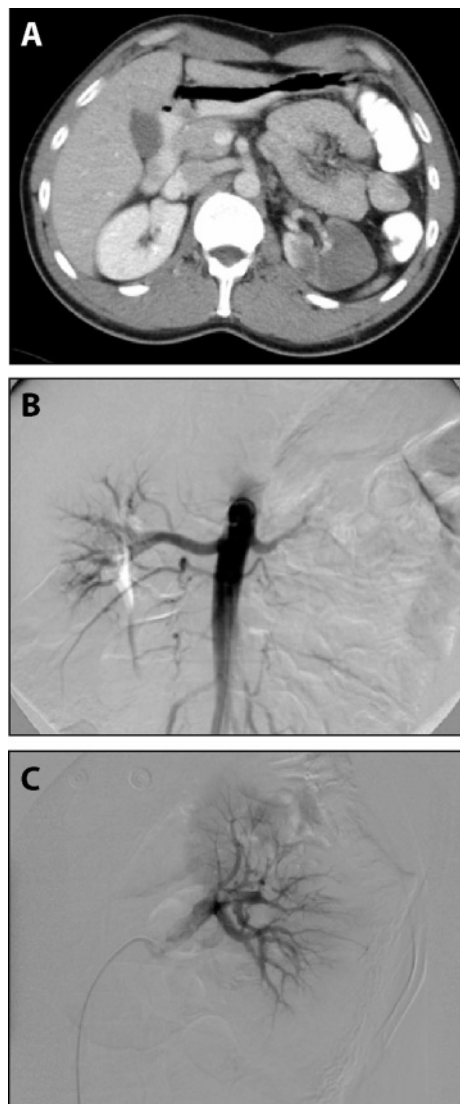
(A) Contrast-enhanced abdominal CT during the late venous phase showing a perfusion deficit of the middle and lower pole of the left kidney. (B) Digital subtraction angiography (DSA) showing a corresponding perfusion deficit of the left kidney during the early filling phase. (C) Good reperfusion after the second cycle of local lysis with rt-PA.
